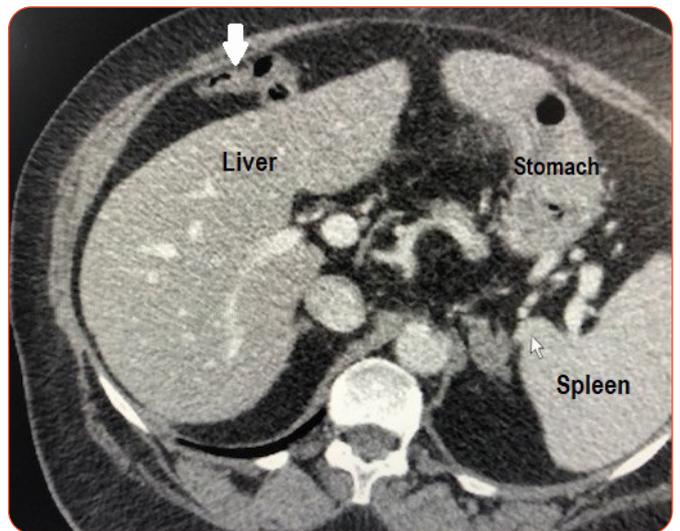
Axial CT showing large bowel (white arrow) above the liver: Chilaiditi sign.
